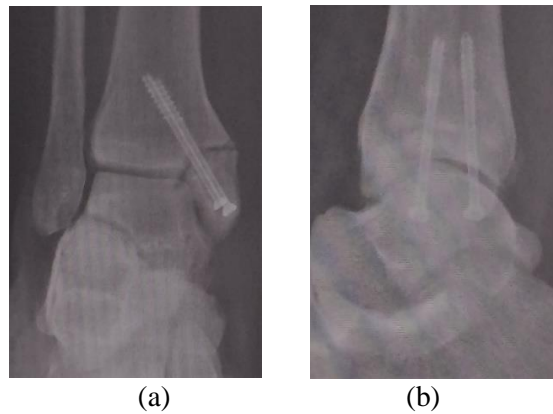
a- AP view of X-ray after 6 months. , b- Lateral view of X-ray after 6 months.
